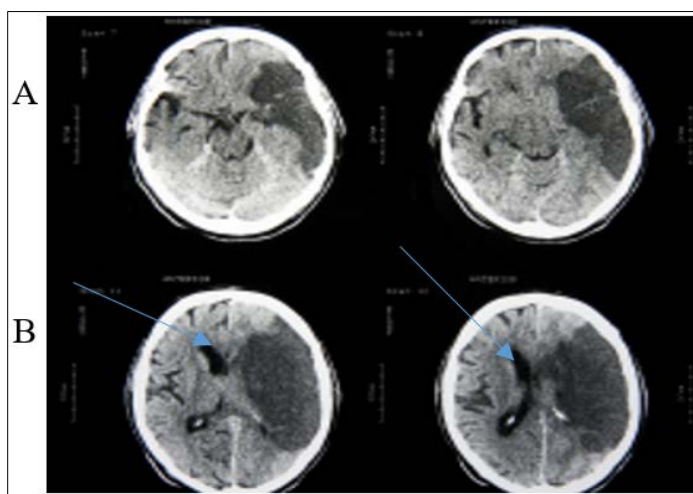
The CT image of normal subjects (A) and patients with infected with Covid-19 with intracranial haemorrhage.
